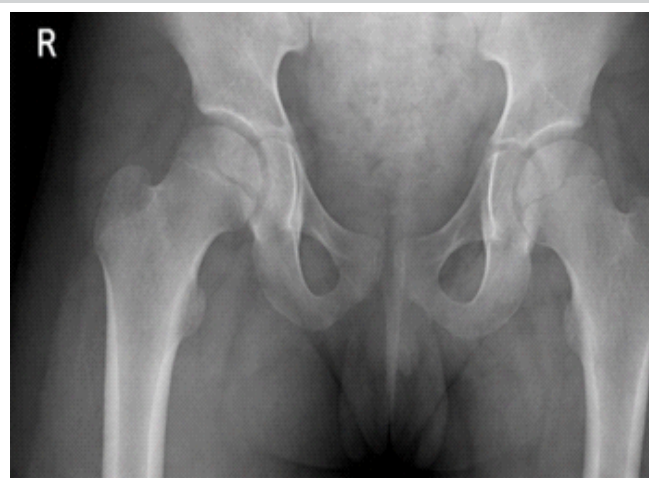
Immediate post-operative radiograph (anteroposterior pelvis) after surgical drainage showing restoration of joint space and improved alignment.
